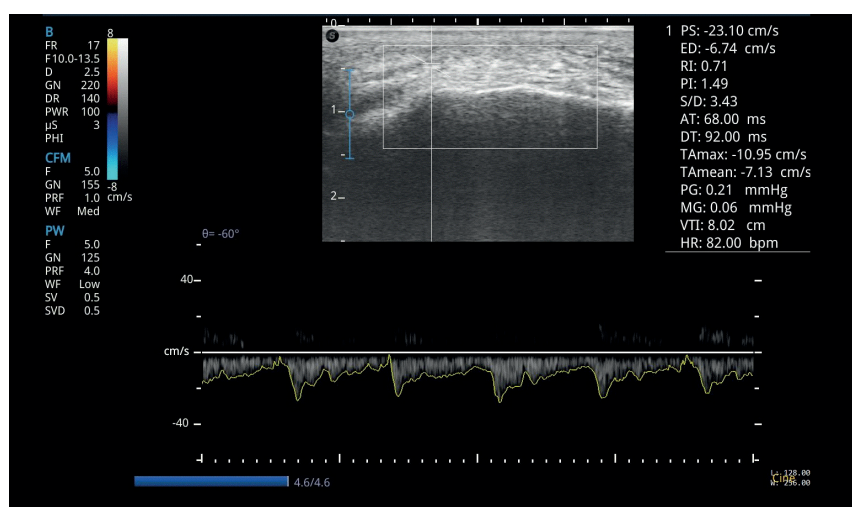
Periodontal tissues Doppler of patient P. of the control group
